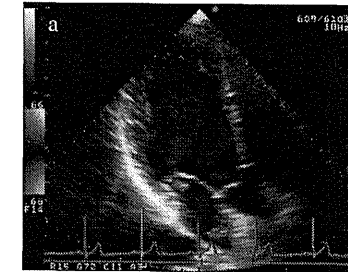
a: conventional color Doppler, b: 2D distribution of blood flow vector obtained by echo-dynamography
